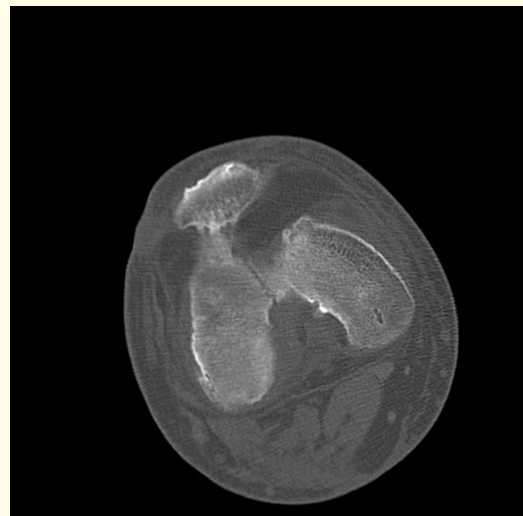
Computed Tomography (CT scan) Knee.
